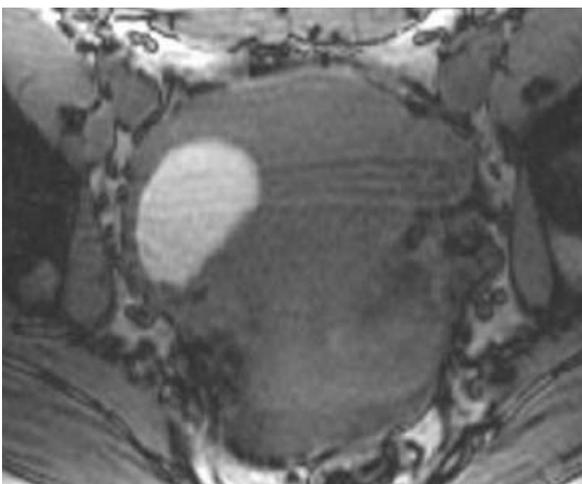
Axial T2-weighted MRI image shows an intermediate to hyperintense signal in the cystic mass (arrow), showing shading, consistent with chronic hemorrhage.
